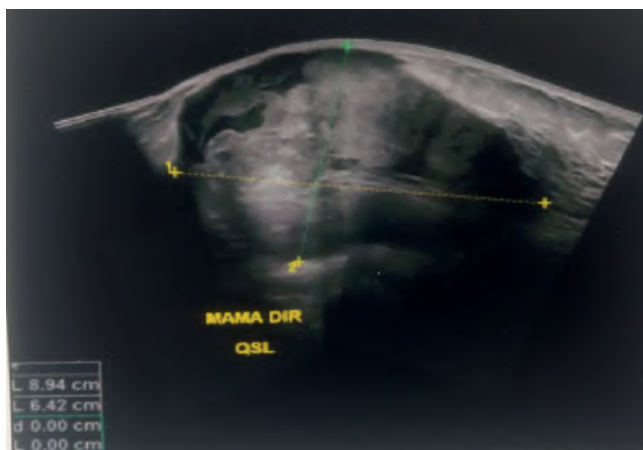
Right breast ultrasonography showing heterogeneous nodular image.
